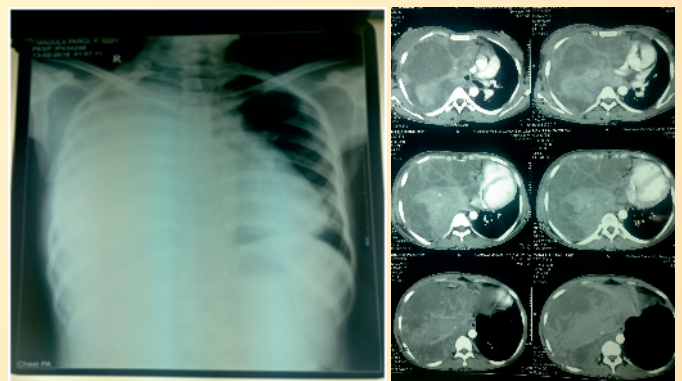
(left) Chest X-Ray suggested of a homogenous opacity in the right hemithorax with mediastinal shift to the contralateral side. Fig 2. (right) CECT Thorax showing heterogeneously enhancing mass like pleural thickening on right side with a thickness of 36 mm with an underlying collapse of the right lung abutting the SVC, severely compressing the right pulmonary artery and its branches, IVC, the right superior and inferior pulmonary veins and right atrium.
